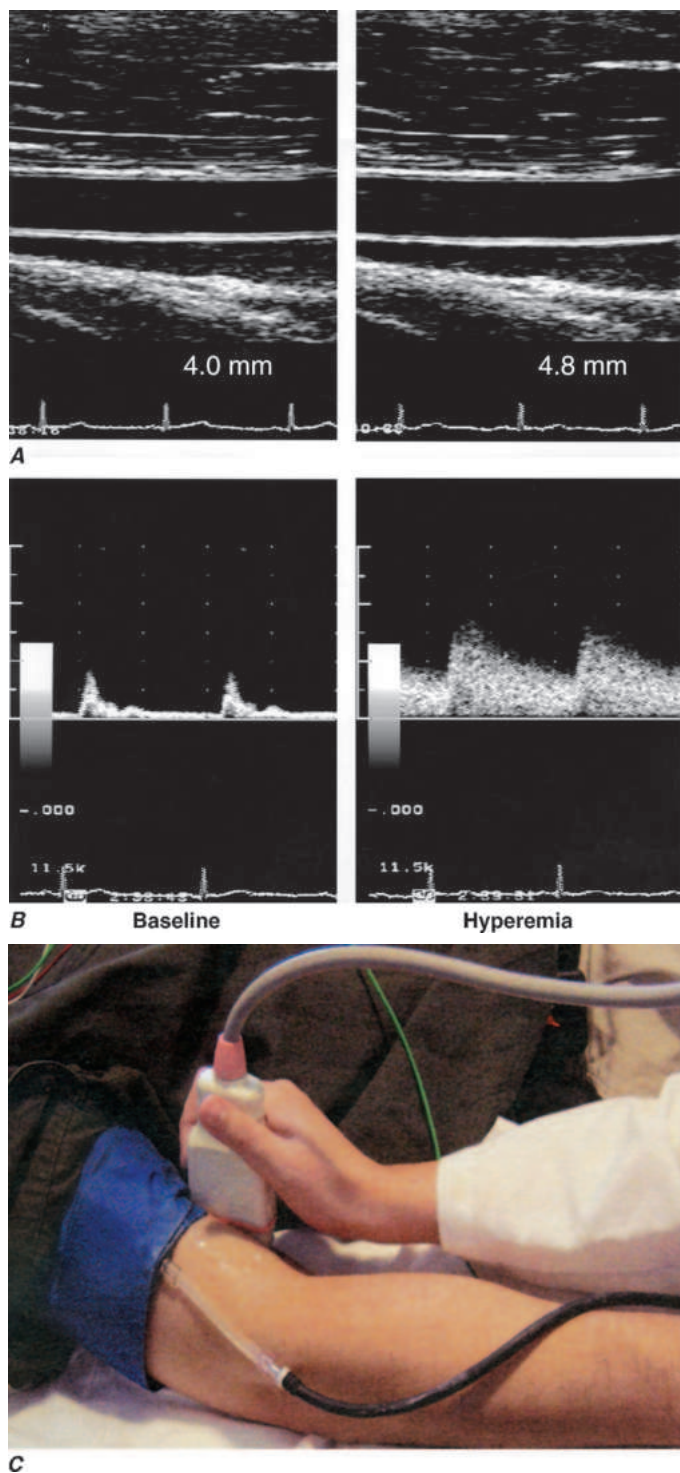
Assessment of endothelial function in vivo using blood pressure cuff occlusion and release. Upon deflation of the cuff, an ultrasound probe monitors changes in diameter (A) and blood flow (B) of the brachial artery (C). (Reproduced with permission of J. Vita, MD.)
